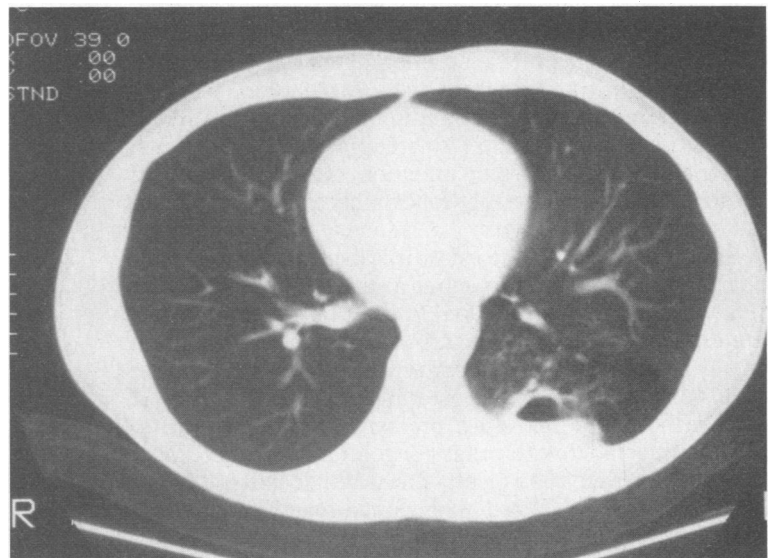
A computed tomographic scan of the chest shows a cavitary lesion with an air-fluid level in the posterior aspect of the left lower lobe. Multiple cysts are seen in the surrounding lung. The second cavity was imaged lower in the thorax.
